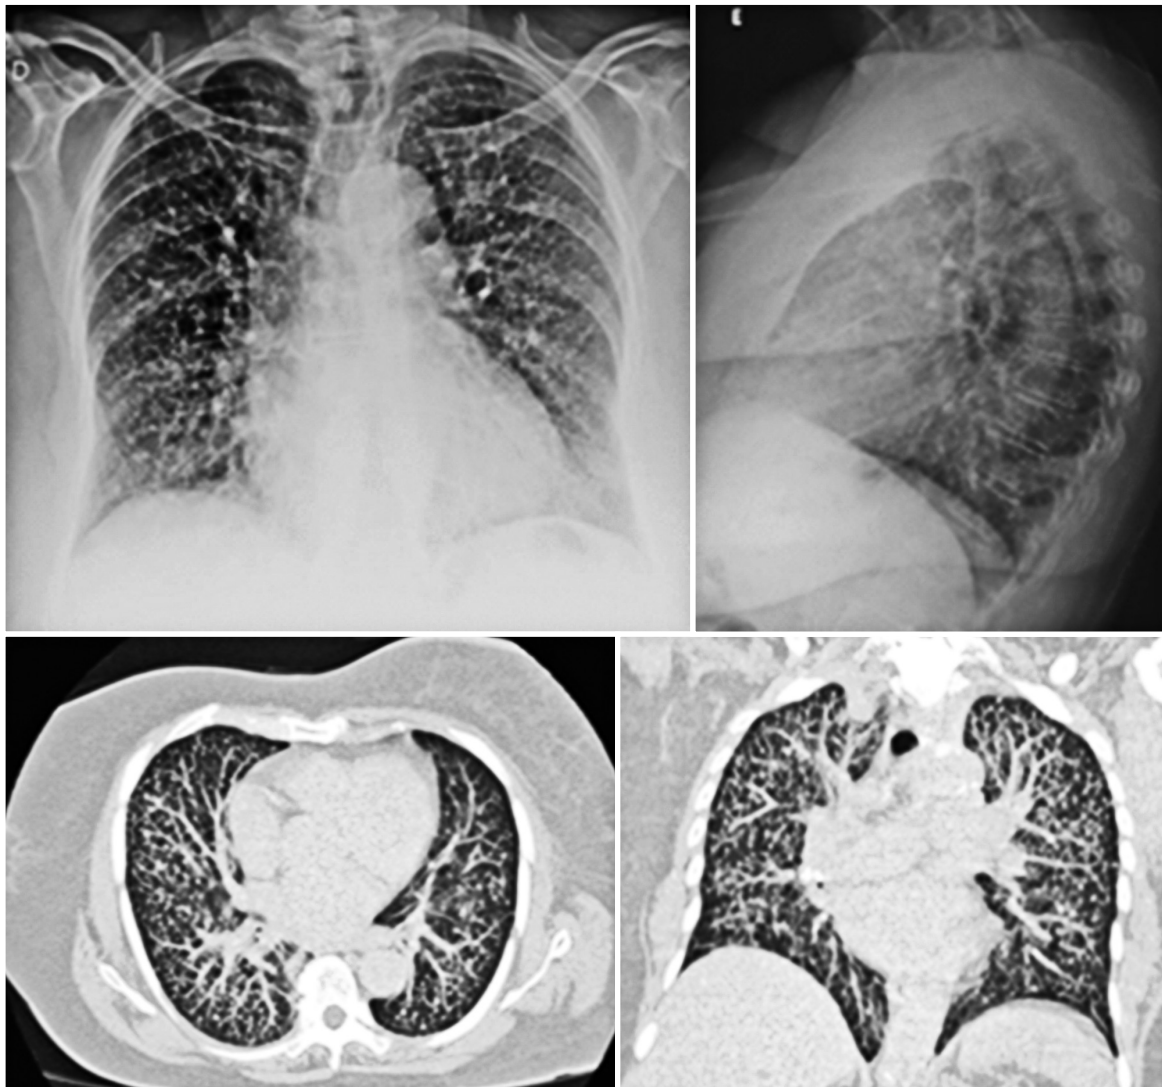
Chest radiography in posteroanterior and lateral views and chest tomography in maximum intensity projection (MIP) processing, showing the random distribution of pulmonary micronodules in axial and coronal sections.
